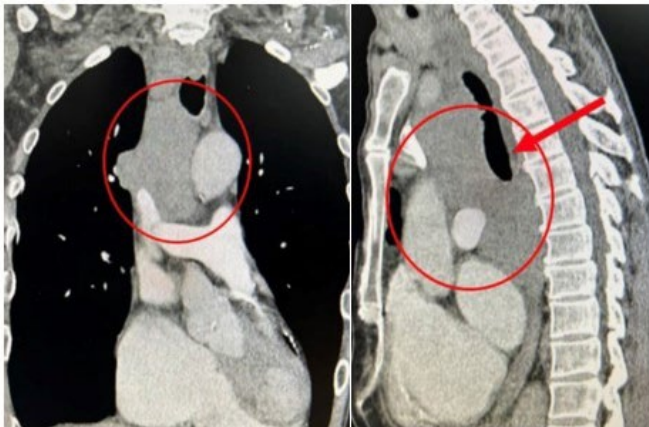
Computed tomography scan A. Coronal view B. Sagittal view showing isodense structure on anterior mediastinum.
